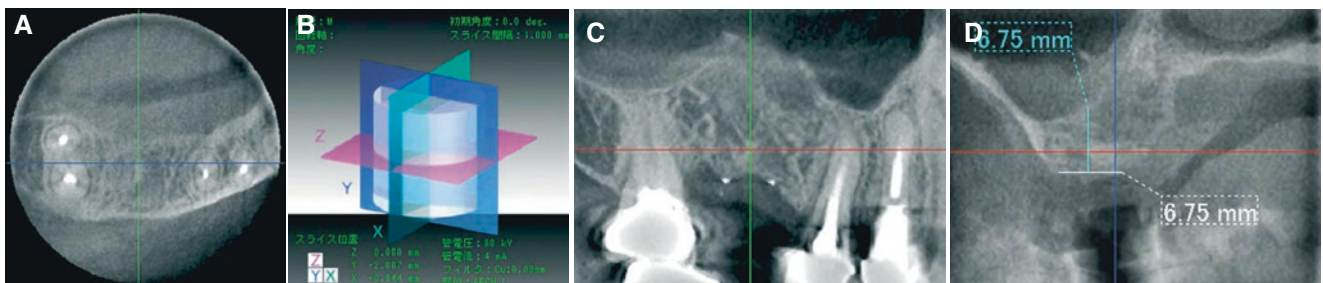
Pre-implant imaging, maxilla; 50-year-old female. (A) Axial CBCT image shows acceptable width of edentulous alveolar ridge. (B) Three image planes indicated by different colors. (C) Sagittal
